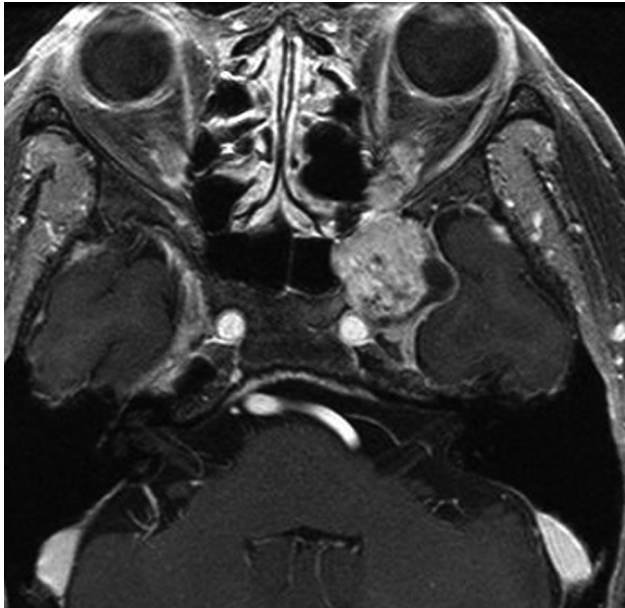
Preoperative magnetic resonance imaging (MRI) in T1-weighted image with contrast enhancement demonstrated a 25-mm mass in the left cavernous sinus protruding to the left orbit via the superior orbital fissure.
